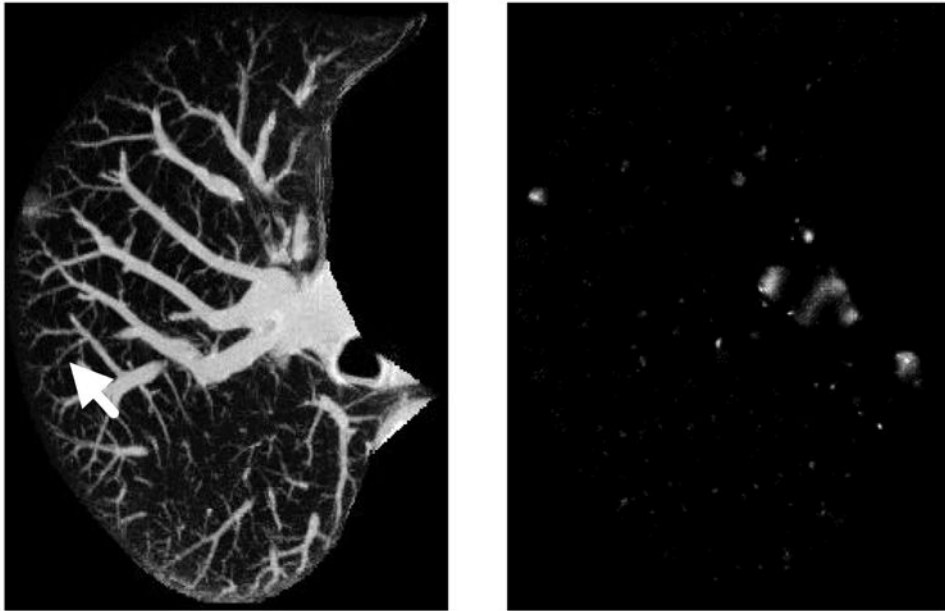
Maximum intensity projection of a 3D CT original image with a cancer, indicated by an arrow, and a nodule-enhanced image, in which the nodule was enhanced and blood vessels were suppressed substantially.
